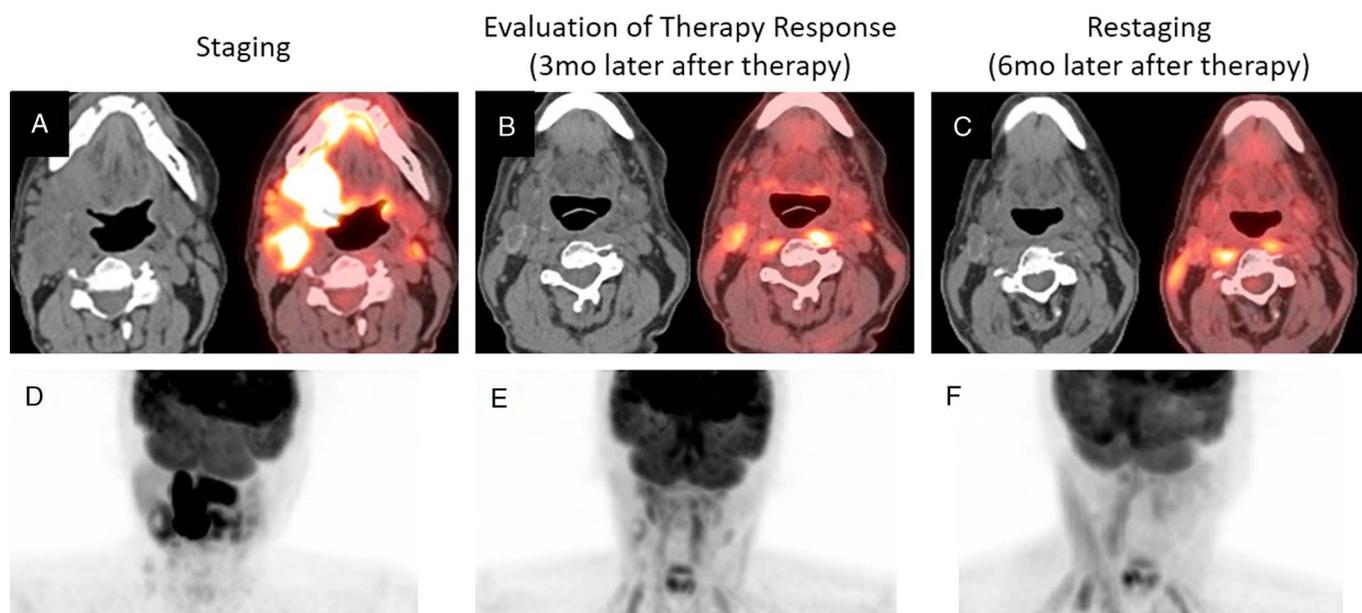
Therapy response–inflammatory uptake. A 61-year-old man presented with p16-negative, squamous cell carcinoma of right tonsil, T4bN2bM0. Axial CT and PET/CT fused images (A) showed FDG-avid left tonsillar primary tumor and bilateral FDG-avid level II lymph nodes. Axial CT and PET/CT fused images (B) showed complete therapy response in the primary tumor with FDG PET/CT, 3 months after finishing CRT. Low-level residual FDG uptake seen within a necrotic right level II node and a small left level II node suggesting residual metabolic uptake, likely posttherapy inflammation. The patient underwent restaging images 6 months after completing the therapy. Axial CT and PET/CT fused images (C) demonstrated decrease in size and FDG uptake of the necrotic right level II lymph node without any therapy. MIP images (D) showed primary tumor with regional metastatic lymph nodes in staging images and complete response of primary tumor and low level residual FDG uptake in bilateral level II lymph nodes after CRT (E) and complete response of primary tumor and bilateral level II lymph nodes in restaging images (F).
